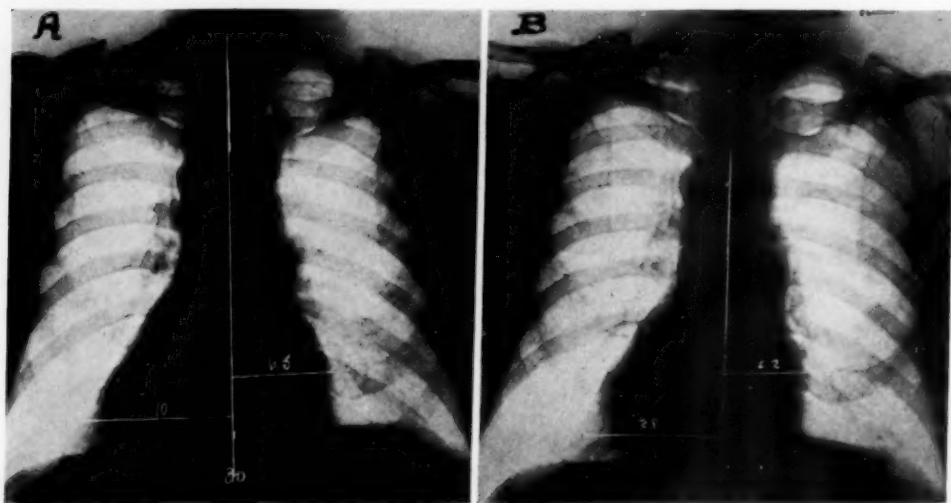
Teleoroentgenograms of the same patient. A—taken 5 weeks after the paracentesis showing further decrease in "cardiac" size. Transverse "cardiac" diameter 16.5 cm., internal diameter of chest 30 cm., CT ratio 55 per cent. B—taken 7 months after A, and 3 months after resection of the colon. The transverse "cardiac" diameter is 14.8 cm., CT ratio 49.3 per cent or normal.
